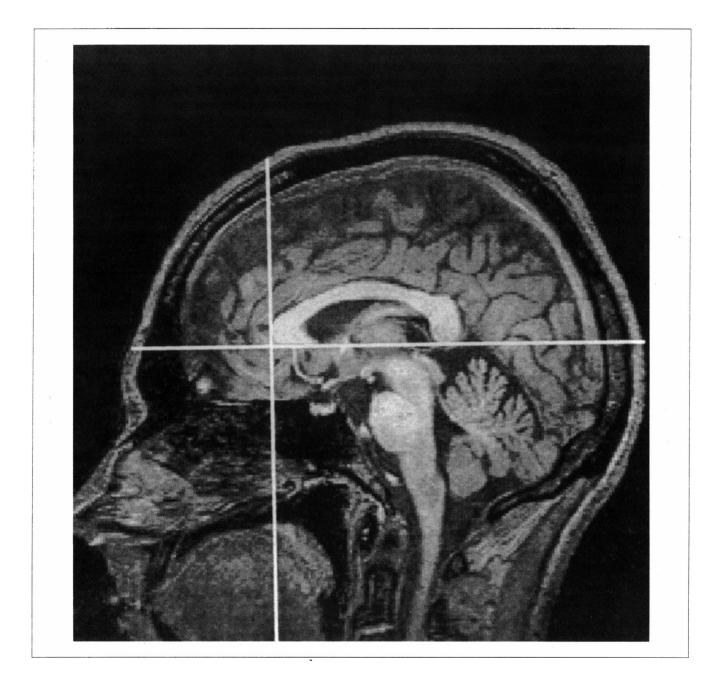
An MRI sagittal image showing a line that passes through the inferior margins of the corpus callosum. The oblique slices were all parallel to this line. The perpendicular line at the rostral edge of the genu of the corpus callosum demonstrates the posterior boundary of the volume of interest for calculating prefrontal volumes.
